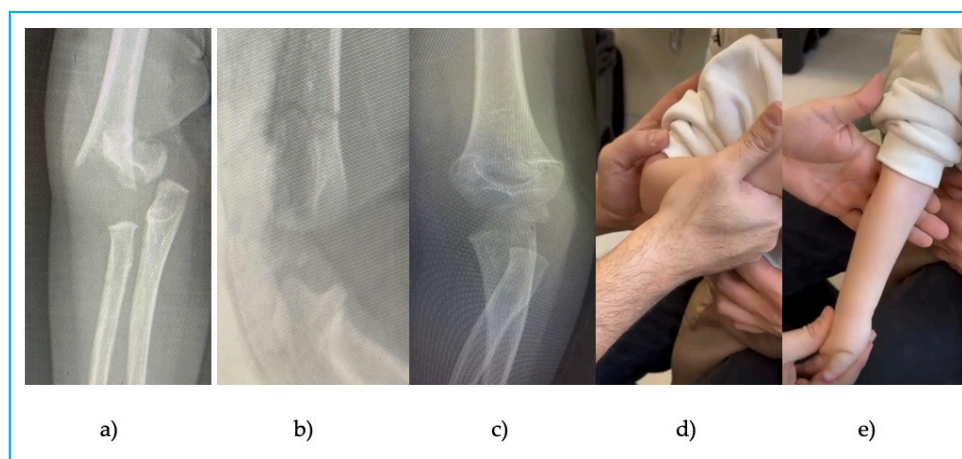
Radiographic and clinical follow-up of a Gartland Type III supracondylar humerus fracture.
